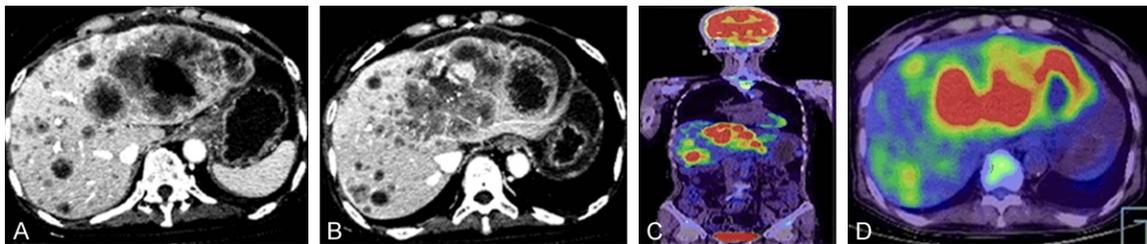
A and B: CT showing a significant increase in tumor size and number, ranging from 2-18 cm in diameter; and a large gas-bearing capsular space (5 cm) with peripheral enhancement in hepatogastric space after treatment with IM and TACE; C and D: Preoperative PET/CT showing multiple hepatic hotspots, no sign of extrahepatic recurrence or metastasis.
